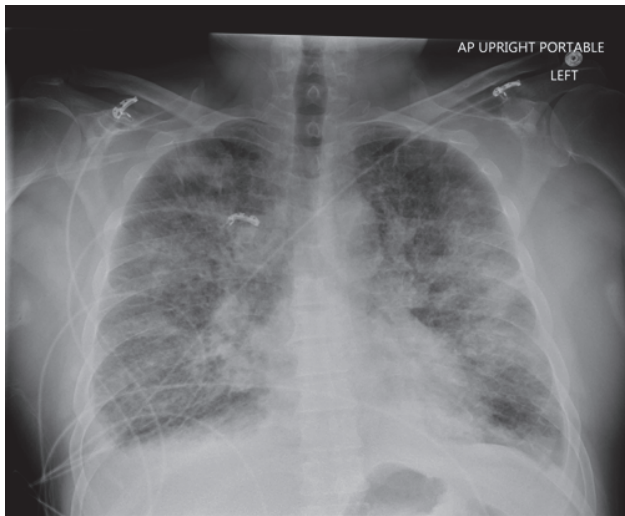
Chest radiograph demonstrating diffuse bilateral infiltrates.
